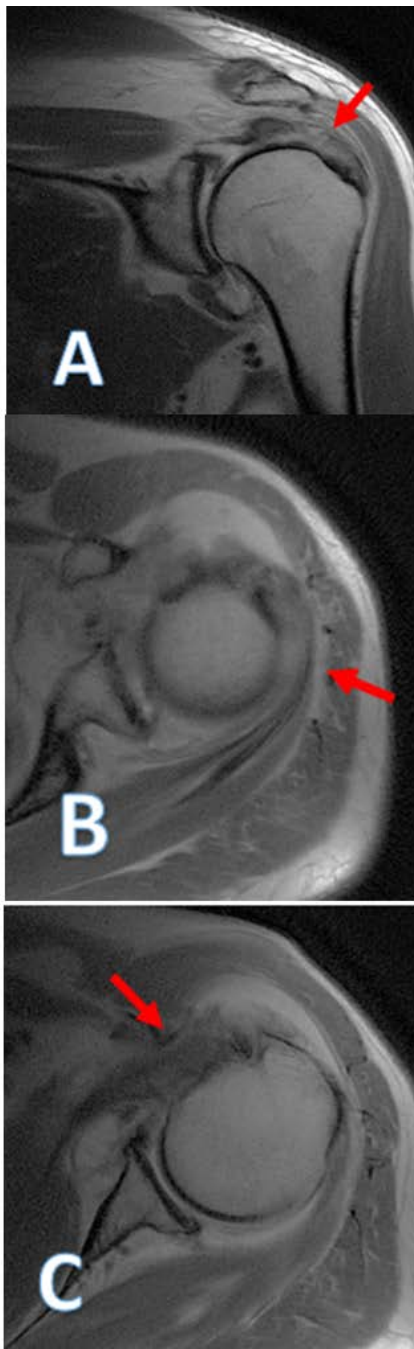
Proton density MR images of the left shoulder joint demonstrating extensive tendinosis and tearing (arrows) of the rotator cuff, involving the supraspinatus tendon on coronal imaging (A), infraspinatus (B), and subscapularis tendons on axial imaging (C)
